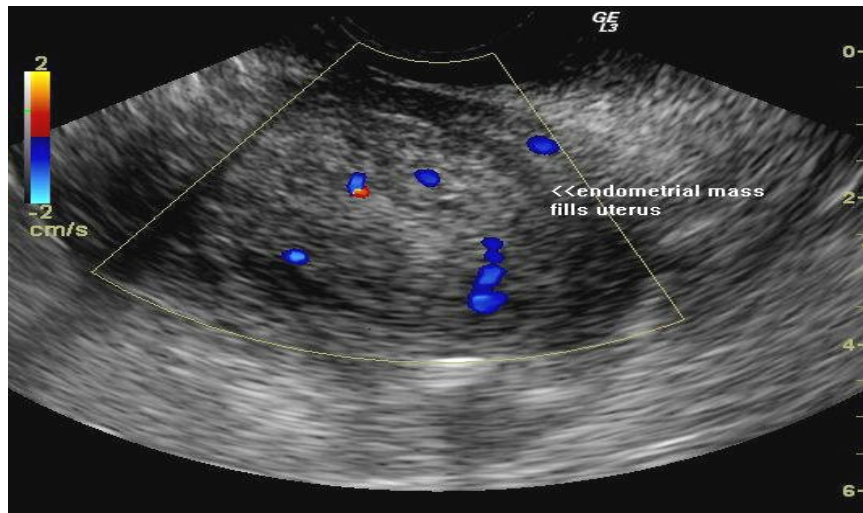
Endometrial Cancer (www.ultrasoundimagegallery.com)
